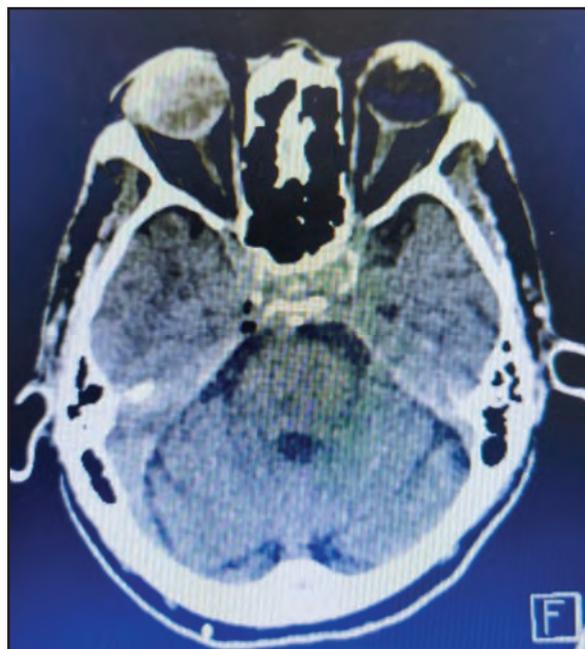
CT scan of the orbit in the axial plane showed a diffuse heterogeneous hyperdensity within the vitreous chamber of the right eye, suggestive of vitreous haemorrhage
